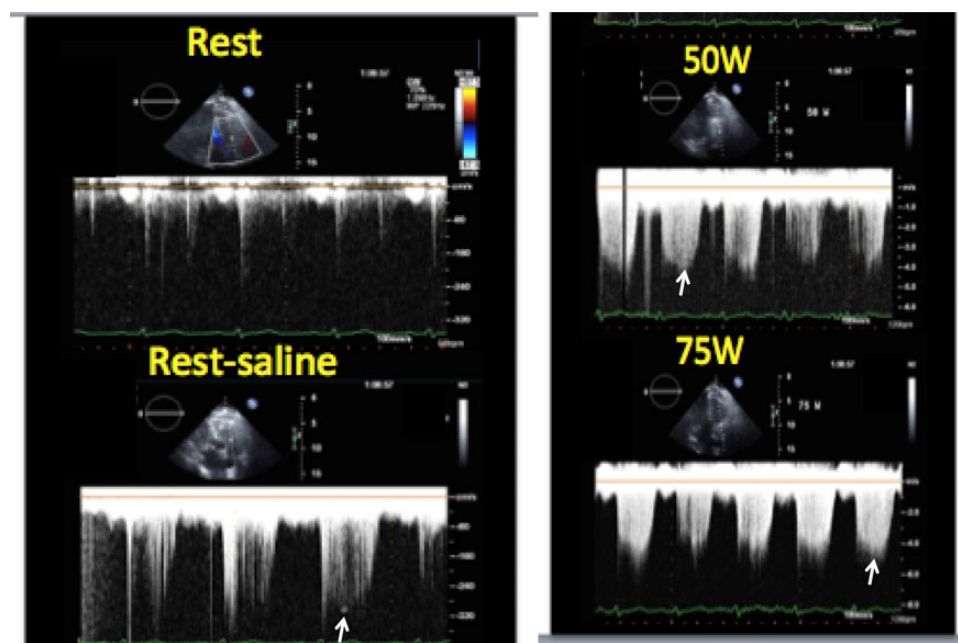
Example of intravenous agitated saline administration in Doppler SE. At rest, there is trivial tricuspid valve regurgitation leading to an incomplete, unmeasurable TR peak velocity. With agitated saline, a complete envelope is present thus allowing the measurement of the peak TR velocity at rest as well as during incremental stages of exercise.
